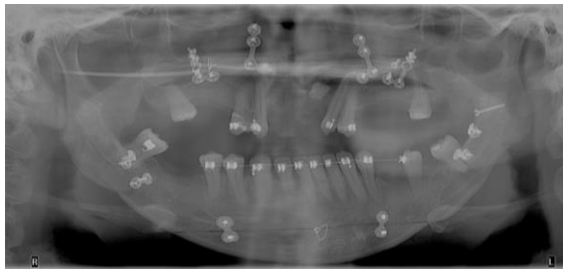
Progress/intermediate panoramic radiograph (post periodontics and orthognathic surgery)
